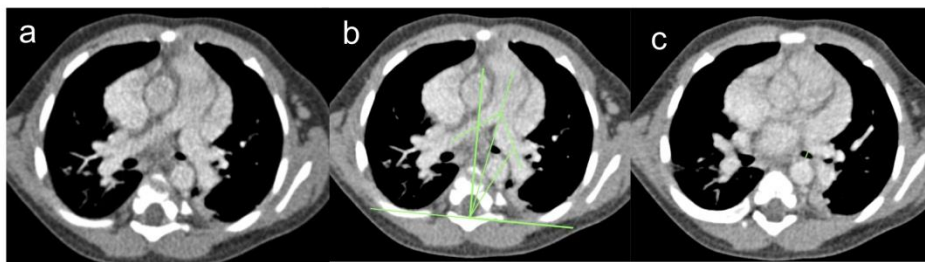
a–c: Sequential CT slices of the chest at the level of the pulmonary outflow tract (a) without and (b) with lines and angles, and (c) at the pulmonary arteries. The narrow bifurcation angle resulting from mediastinal shift to the right in this child with pulmonary TB and right sided volume loss results in compression of the left main bronchus by the left main pulmonary artery against the aorta.
